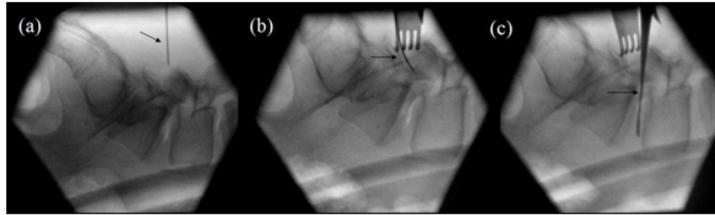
Intra-operative (Step 3) X-ray Shows Hooks (Arrows) at the Superior and Inferior Margins of Decompression.
